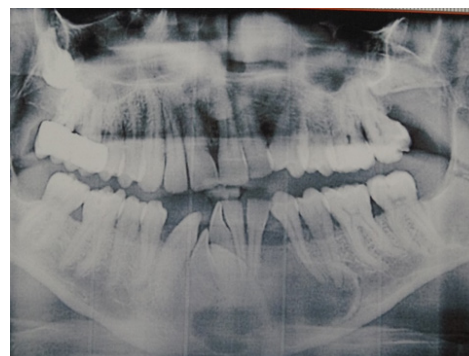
Orthopantomogram, revealed multiple cysts in the mandible, more on the left side, crowded, and conical teeth.
